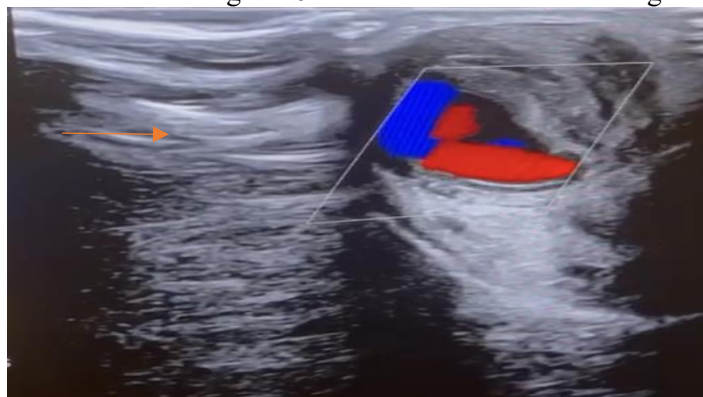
Doppler Ultrasonography of the Swelling
